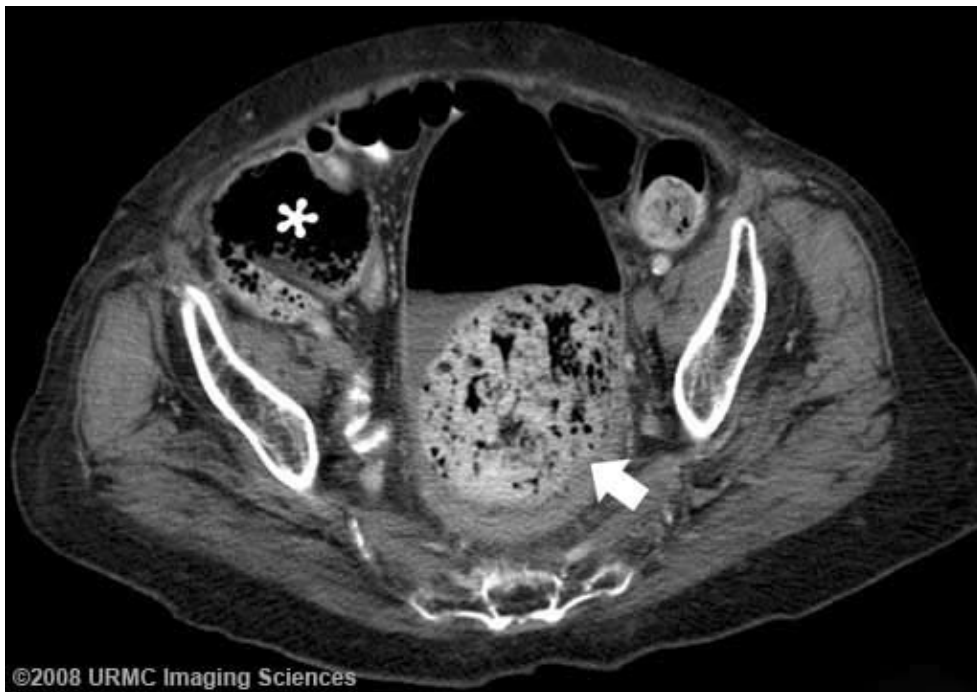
(Case 1): CT at the level of the pelvis demonstrates a large fecolith in the rectosigmoid region (arrow). Note cecum is also dilated consistent with colonic obstruction (asterisk).
